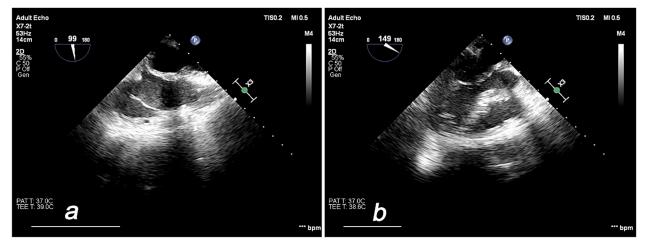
(a and b) Postsurgical 2D transthoracic echocardiography showed the absence of the tumoral mass, no shunt at the site of the interatrial septum and a competent mitral valve. 2D: Two-dimensional.
